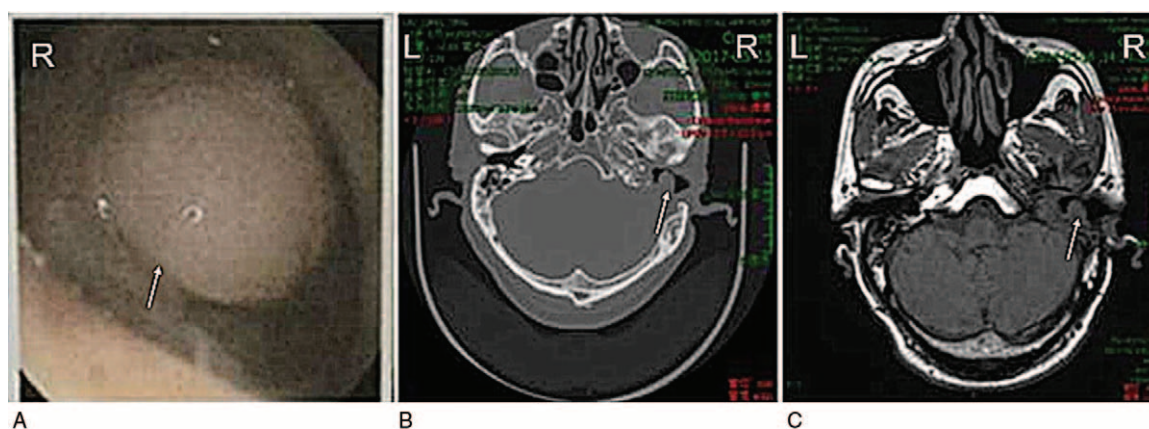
(A) Endoscopic examination showing smooth surface reddish neoplasm in the right ear external auditory canal. (B) CT of the middle ear mastoid showing right middle ear soft tissue shadow and bone destruction. (C) Middle ear scan and enhanced MRI showing right middle ear tumor after surgery, right middle ear-inner ear abnormal signals, and right external auditory canal nodules, confirming chronic inflammation of the surgical region and nodular lesion of the external auditory canal. CT=computed tomography, MRI=magnetic resonance imaging.
